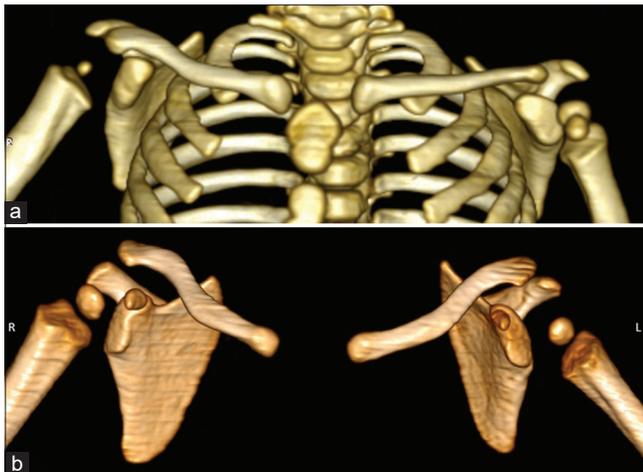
Computed tomography virtual reality images. (a) Child with the right obstetric brachial plexus injury (OBPI) with hypoplastic right humeral head, absent greater tuberosity epiphysis and retroverted right glenoid cavity. (b) Child with the left OBPI with hypoplastic and retroverted left glenoid cavity.
